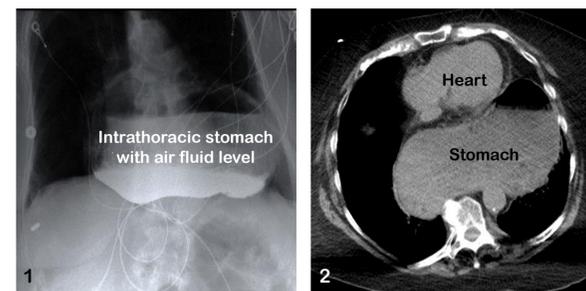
Intrathoracic stomach with air fluid level on esophagram (1) and on CT scan (2)
